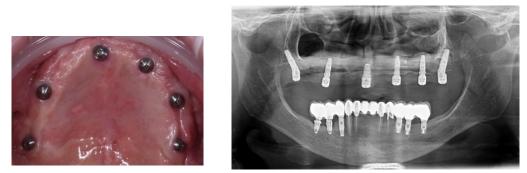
A control orthopantomography showing the inserted implants and pins stabilizing membranes.
